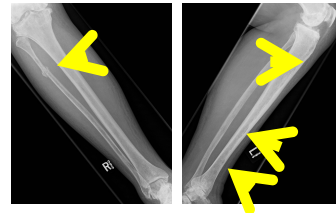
Frontal plain radiograph view of the right lower leg demonstrates a lytic lesion in the fibula with a pathologic fracture in the proximal tibia.
